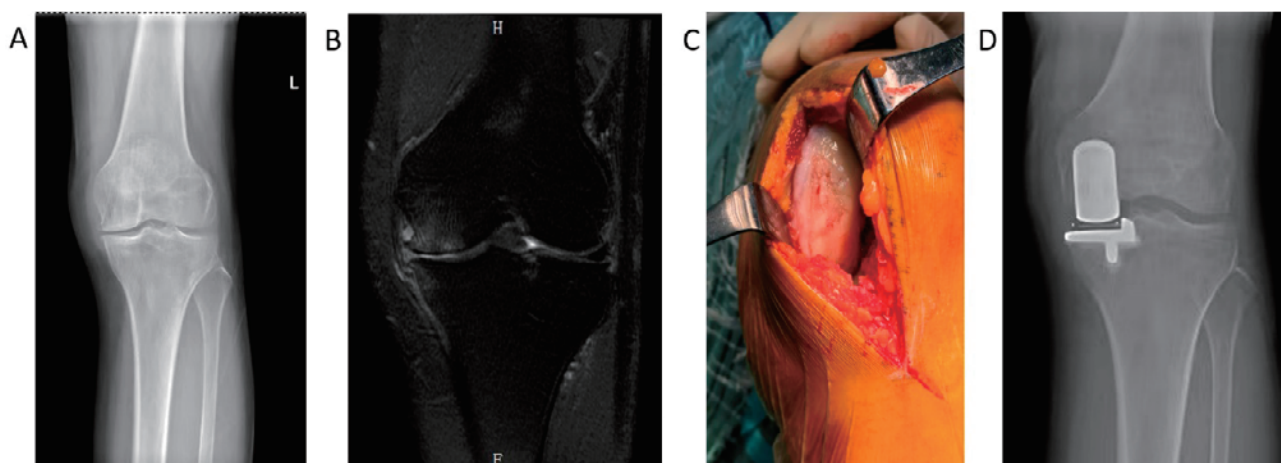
Imaging findings from the patient. (A) Preoperative radiograph of the knee. (B) Preoperative MRI of the knee. (C) Intraoperative photograph showing severe degeneration of femoral lateral condylar cartilage. (D) Postoperative radiograph of the knee.
